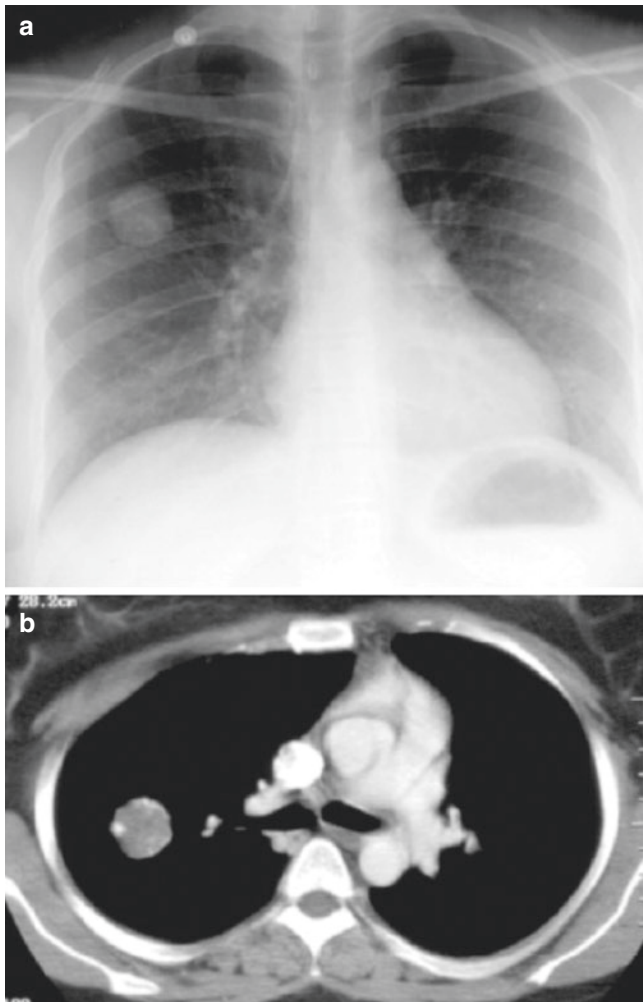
An 18-year-old girl with a pulmonary chondroma. (a) Routine preoperative chest radiograph and (b) axial enhanced CT image show a well-circumscribed soft tissue mass with a coarse calcification in the periphery of the nodule
